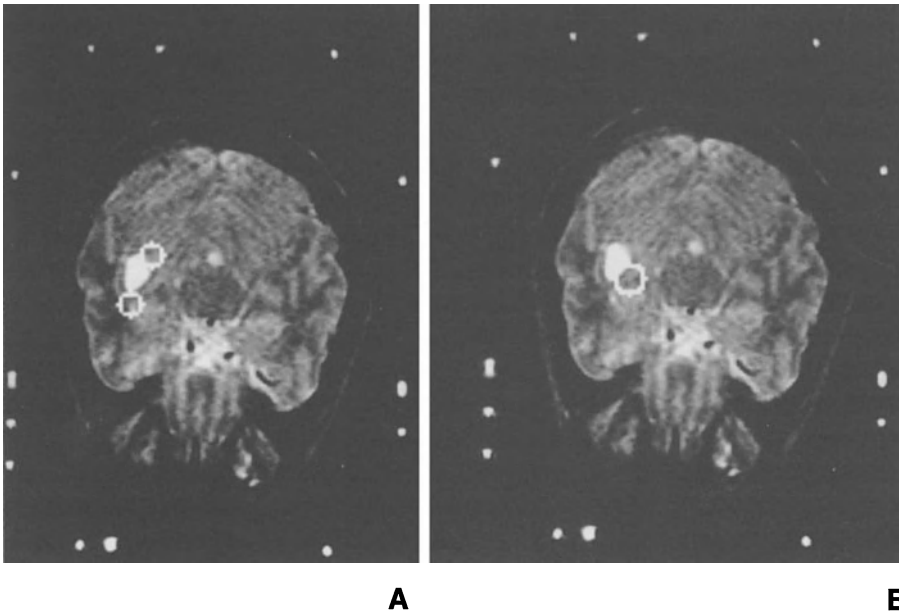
Stereotactic MRI in the patient with partial complex seizures. (A) Before Gamma Knife radiosurgery. The two rings indicate origin of interictal epileptic activity revealed by MEG and digitally transferred to the MRI image. (B) Six months after radiosurgery when the patient was seizure free. Note absence of one interictal seizure focus and diminished volume of cyst
